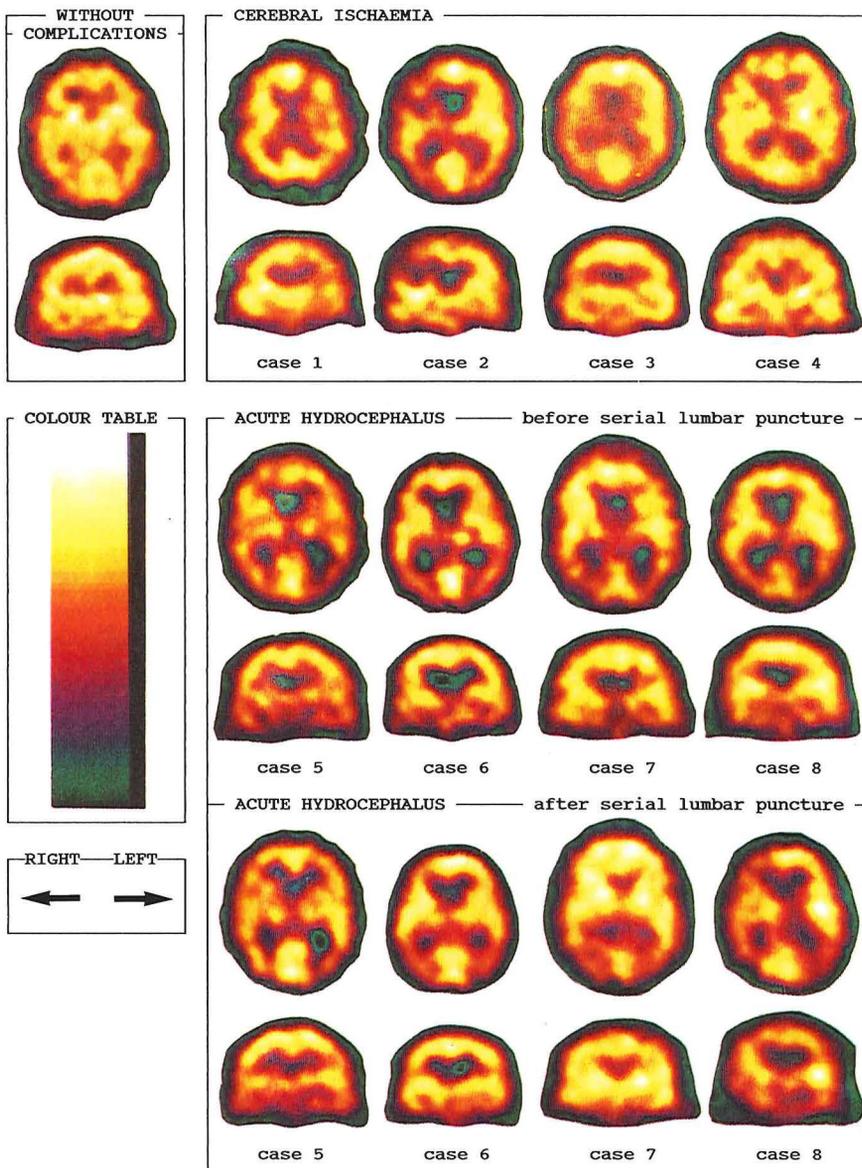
Results of single photon emission computed tomography in patients with cerebral ischemia and in those with acute hydrocephalus after subarachnoid hemorrhage.
